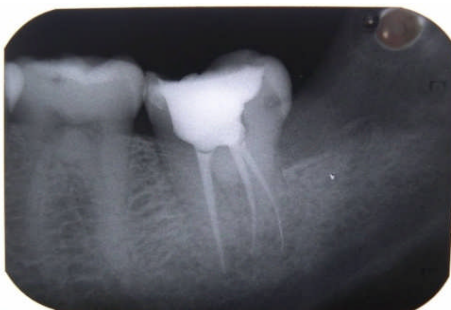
Follow up radiograph.
